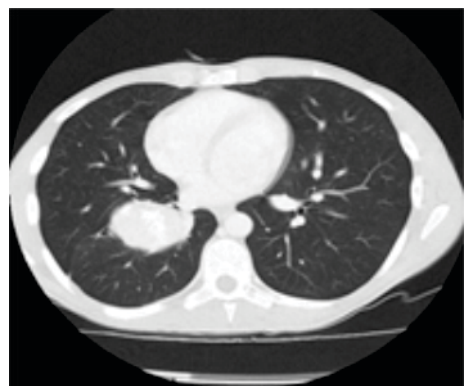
CT image of one of the study subjects showing right large heterogenous enhancing mass lesion with hyperdense foci calcifications.
